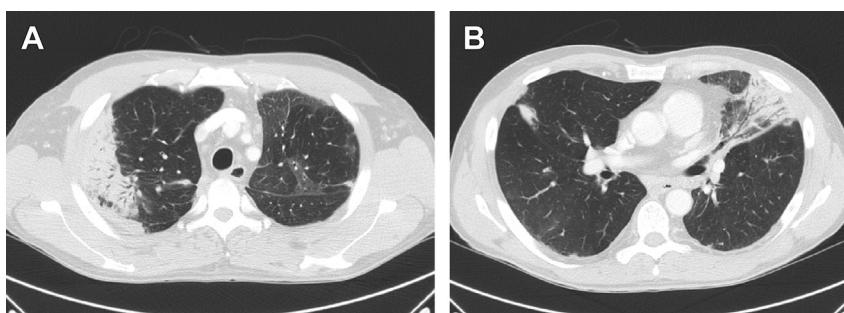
Chest CT of a patient with ICEP, demonstrating peripheral airspace consolidation predominating in the upper lobes. (A) Right upper lobe; (B) lingula.
